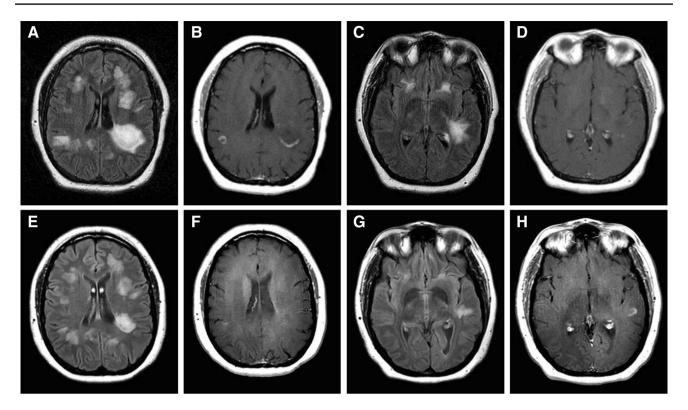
New lesions on early brain MRI. New lesions on early brain MRI in a 31-year-old patient with multiphasic disease. Axial T2-FLAIR ( $\mathbf{a}, \mathbf{c}$ ) and T1-post contrast ( $\mathbf{b}, \mathbf{d}$ ) images of the brain show multifocal large and small lesions in the bi-hemispheric subcortical white matter. Some of these lesions have an open-rim of enhancement including a large edematous lesion in the left parietal lobe ( $\mathbf{b}$ ). Other
